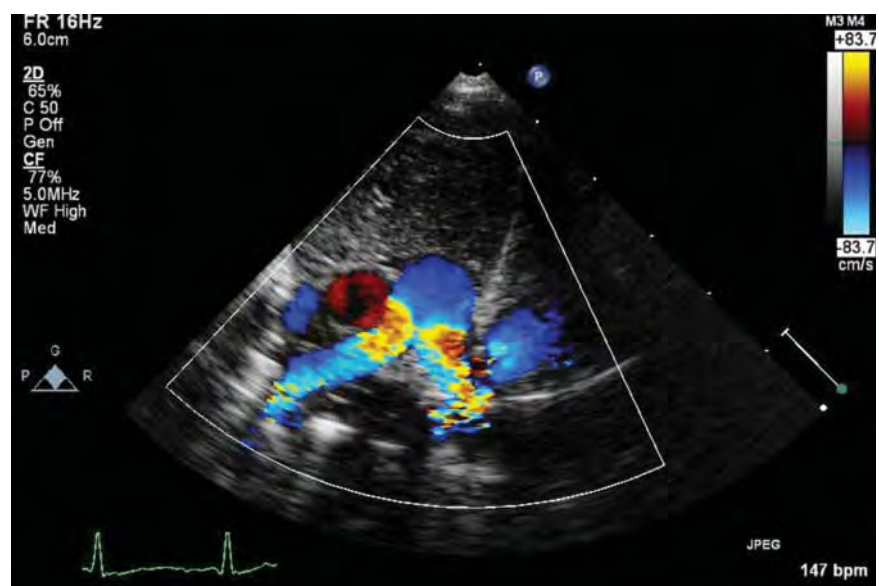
High parasternal short axis color Doppler image of flow acceleration at the origin of the branch pulmonary arteries.
